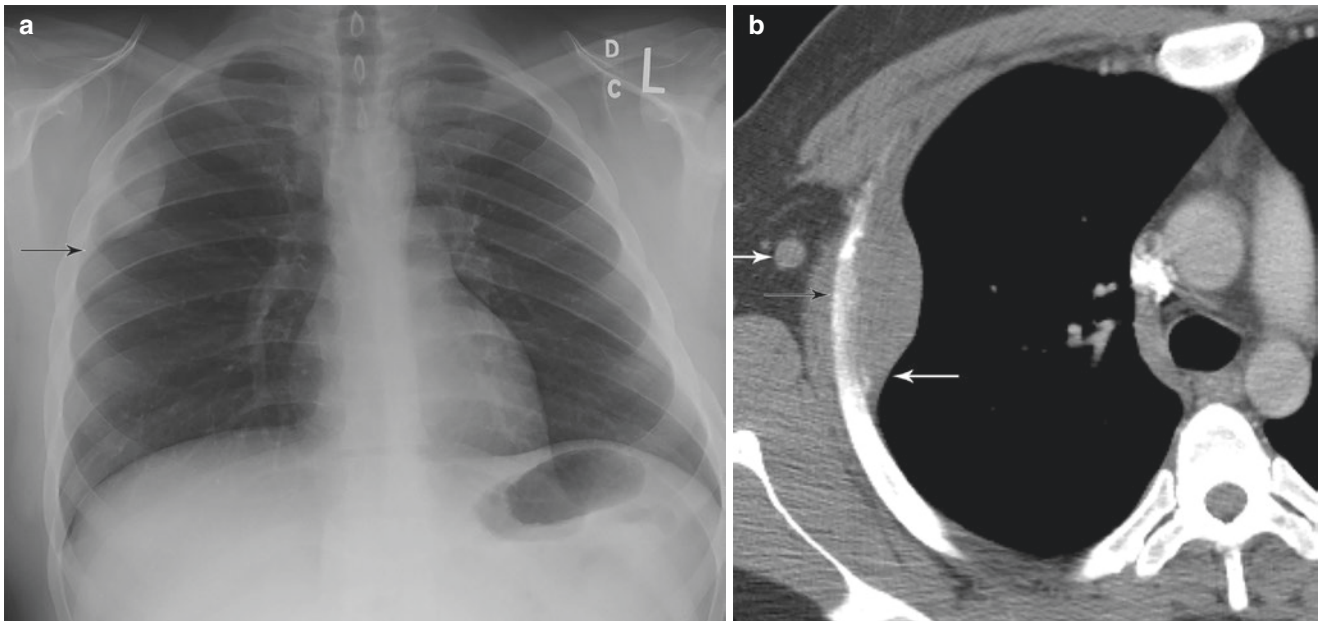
(a) Frontal chest radiograph shows the right pleural metastasis forms obtuse angles (arrow) with the chest wall. In contrast, lung lesions that abut the pleura form acute angles with the chest wall; (b) contrast-enhanced axial CT shows the right pleural metastasis forms obtuse angles with the chest wall (long white arrow) and is associated
